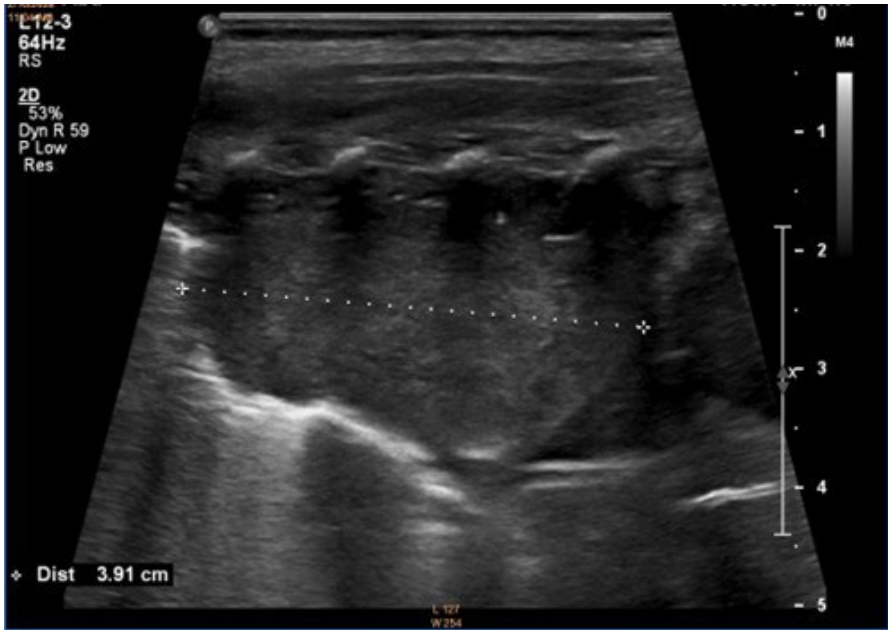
The solid structure revealed in lung ultrasound
